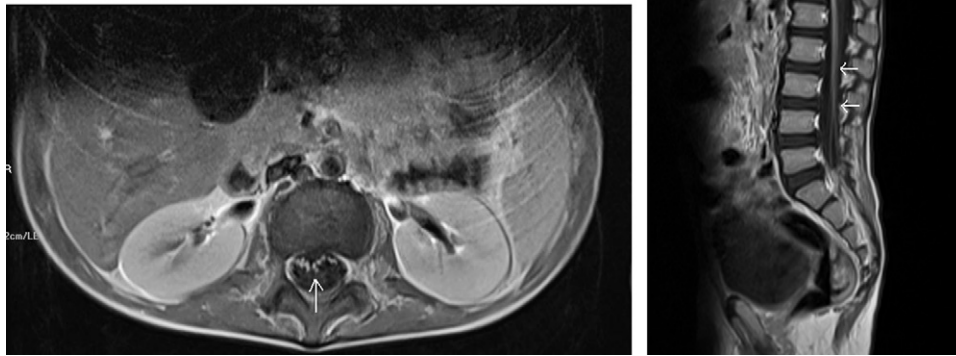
T₁-weighted postcontrast axial (A) and sagittal (B) magnetic resonance image of the cauda equina reveals smooth, diffuse enhancement of the nerve roots.
